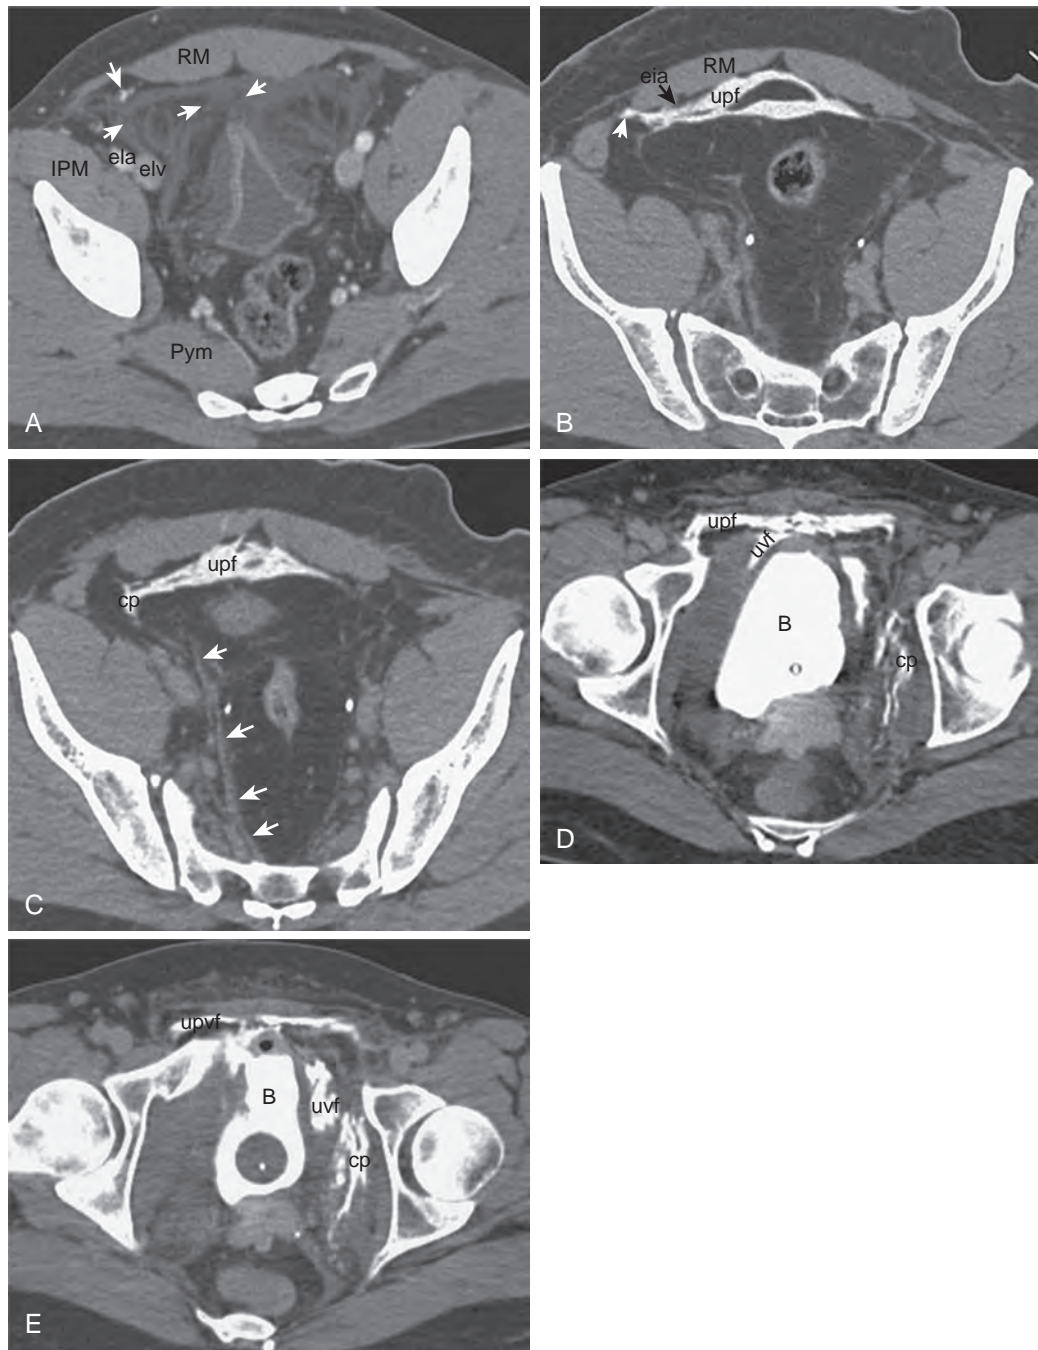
Retroperitoneal fascial planes. A. CT section of a patient with traumatic bladder perforation shows a small amount of urine in the perivesical space (pvs) surrounding the bladder (B). In this patient, there is a larger fat plane than usual around the medial umbilical ligament (mul). There is fluid within the umbilicoprevesical fascia (upvf) anteriorly and the umbilicovesical plane (uvp) posteriorly. On the right, the collection extends posteriorly toward the internal iliac vessels lying on the piriformis muscle (Pym). Anteriorly, the lateral part of the fascia extends posterior to the internal epigastric artery (iea) to blend with the combined plane (cp) near the external iliac vessels (eia and eiv). The iliopsoas muscle (IPM), rectus abdominis muscle (RM), and urachus (ura) are indicated. B. CT section in a different patient with a pelvic fracture producing extraperitoneal bladder perforation shows another pattern of fluid distribution in the pelvic extraperitoneum. Contrast material from the bladder has extended into the umbilicoprevesical fascia (upf), which divides in the midline to surround the fat surrounding the median umbilical ligament or urachus (ur). The umbilicoprevesical fascia extends laterally behind the external iliac artery (eia) and enters the transversalis fascia (tf) lateral to the boundary of the rectus abdominis muscle (RM). C. CT section obtained 15 mm inferior to that in B shows contrast material in the umbilicoprevesical fascia (upf) extending into the combined plane (cp) on the anterior surface of the fat around the medial umbilical ligament (mul). On the right, fluid, but not contrast material, extends posteriorly (arrows) just medial to the iliac vessels and lateral to the perirectal fat as far as the presacral space (PS). D. The CT section in another patient with extraperitoneal bladder rupture due to blunt trauma with multiple pelvic fractures shows contrast material from the perforated bladder (B) extending into the umbilicovesical fascia (uvf) and the umbilicoprevesical fascia (upf). On the left, some of this contrast material has entered the combined plane (cp), tracking posteriorly. E. A CT section 15 mm inferior to that in D shows further accumulation of contrast material in the combined plane (cp).
